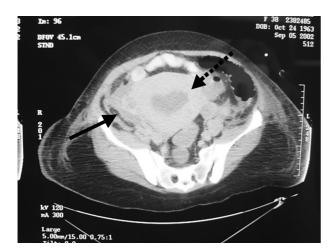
An abdominal computed tomography (CT) scan on hospital day 8 shows an enlarged uterus (dashed line) and a complex fluid collection along the inferior aspect (solid line).
